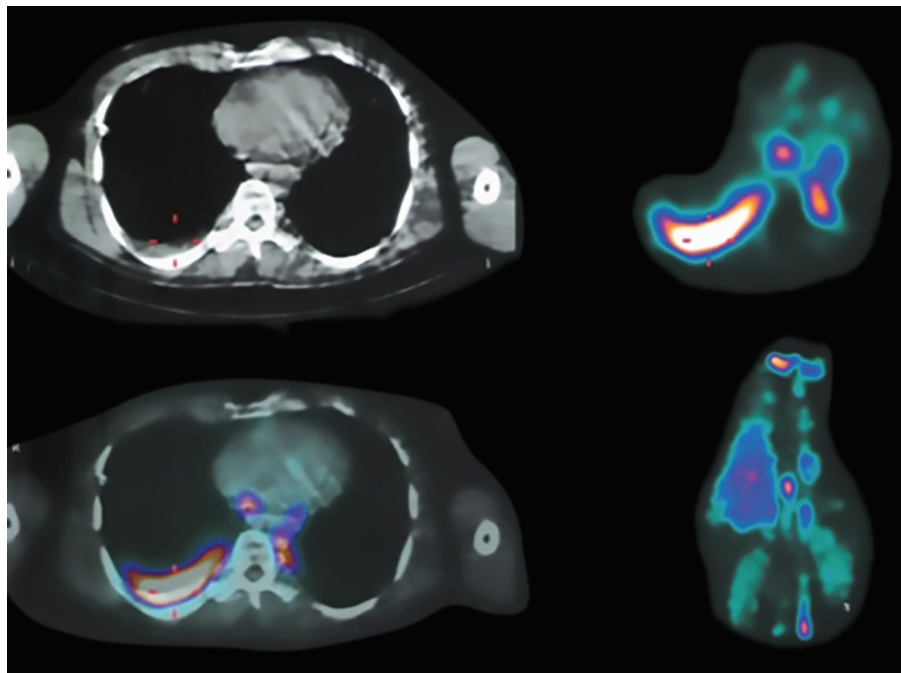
The SPECT image showing significant tracer uptake in right pleural cavity and abnormal dilated lymphatic channels in the left prevertebral, paraaortic, left supraclavicular regions with mild tracer up
